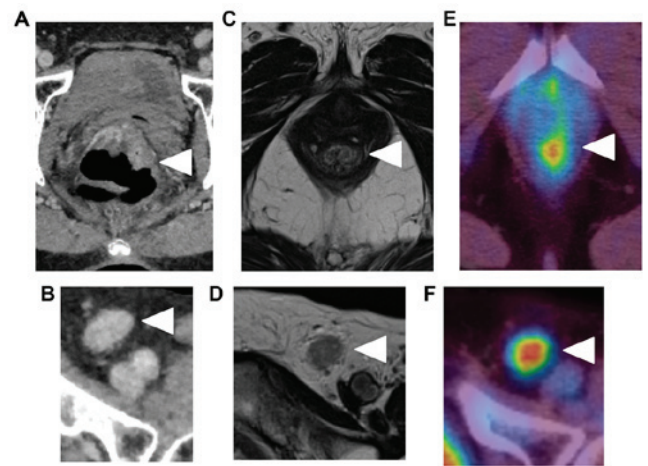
Main tumor and left inguinal lymph node. (A) Thickness of the lower rectum wall (arrowhead) in the abdominal CT. (B) Left inguinal lymph node of 15 mm in diameter (arrowhead) detected by the abdominal CT. (C) Thickness of the lower rectum without evident invasion into muscular propria (depth, T1; arrowhead), identified by MRI. (D) Left inguinal lymph node of 15-mm in diameter (arrowhead) revealed by MRI. (E) Lower rectum tumor (arrowhead) confirmed by PET. (F) Left inguinal lymph node (arrowhead) confirmed by PET. CRT, chemoradiotherapy; PET, positron emission tomography.
